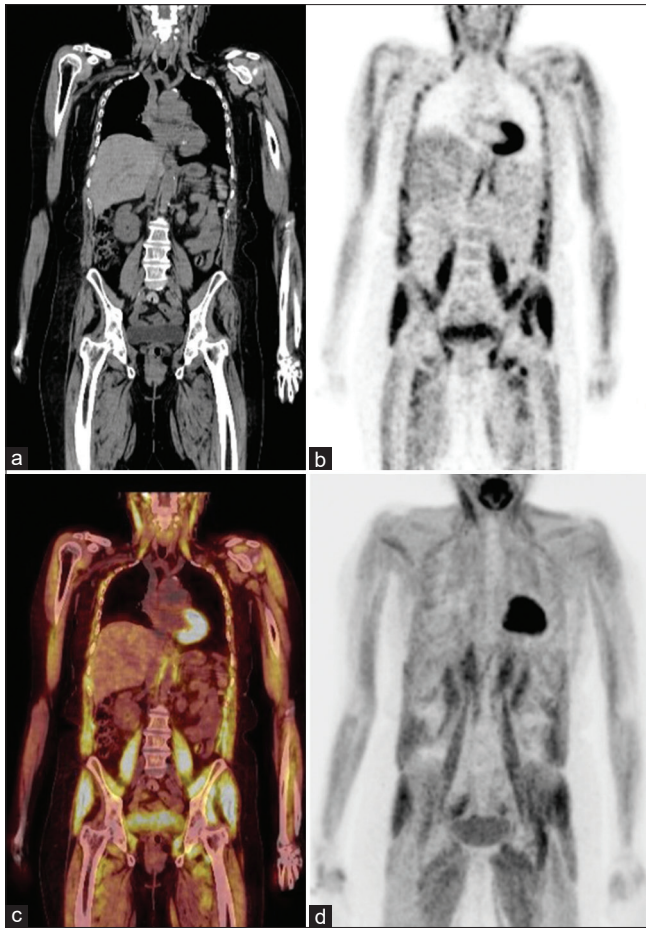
Coronal CT (a), coronal PET (b), coronal fused PET CT (c), MIP (d) F-18 FDG PET/CT showing intensely hypermetabolic whole-body muscle uptake. F-18 FDG PET/CT: <sup>18</sup>F-fluorodeoxyglucose positron emission tomography/computed tomography, MIP: Maximum intensity projection
